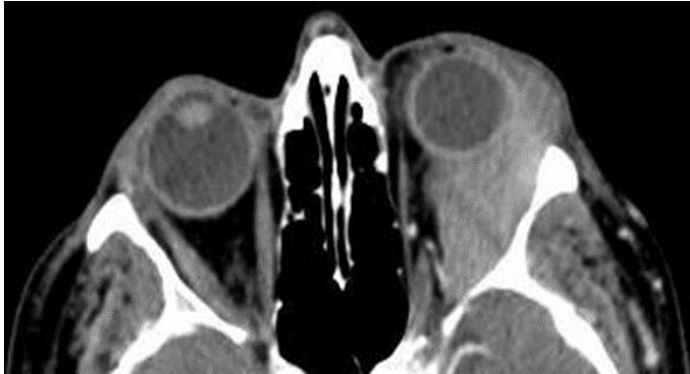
Patient K, 74 years old, post-contrast computed tomography fragment
